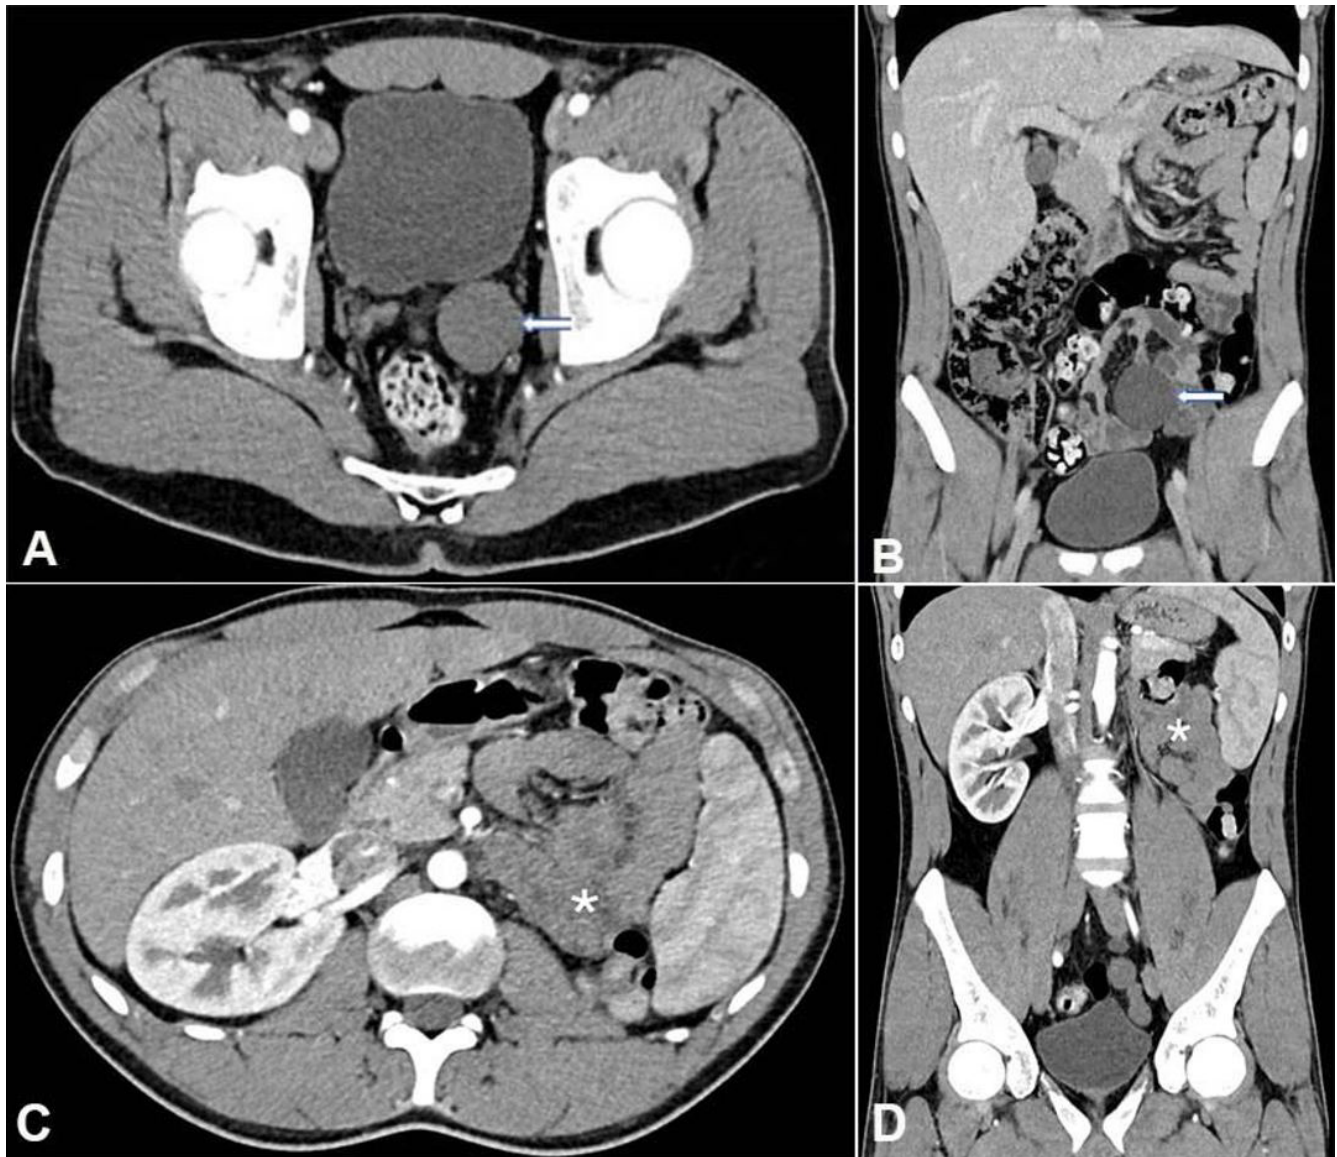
abdominopelvic CT. A – axial plane; B – Coronal plane – showing seminal vesicle cyst (arrow); C – axial plane; D – Coronal plane – showing left renal agenesis (asterisk).
